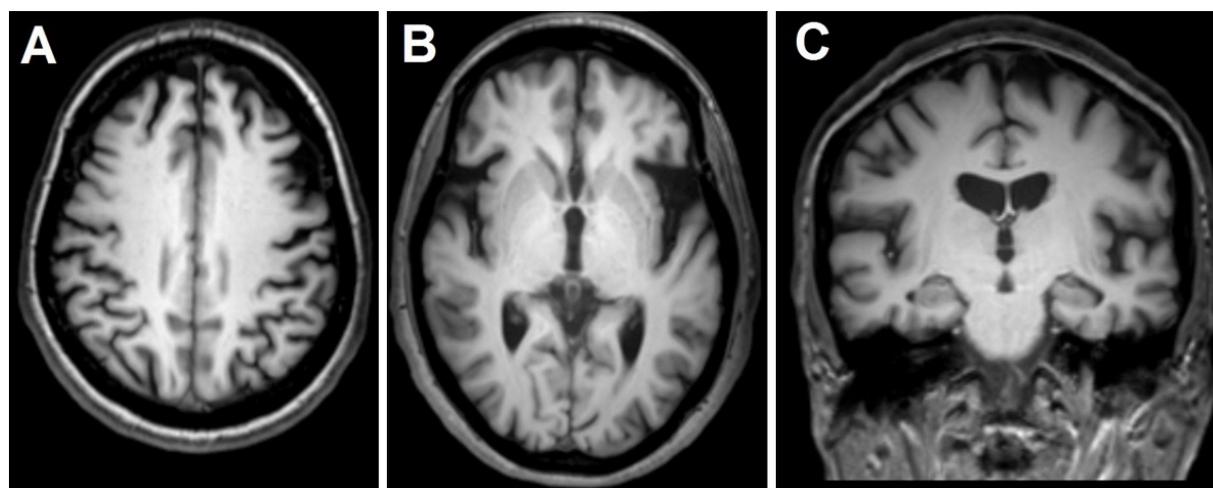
Brain magnetic resonance imaging (T1 sequence) of case 5, showing frontal frontoparietal and sylvian atrophy more evident to the left (A,B) with preservation of the hippocampus (C)
